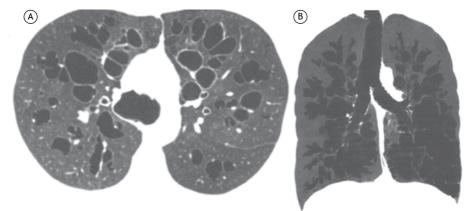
In A, chest CT during inspiration showing bilateral bronchiectasis, in addition to marked dilation of the main bronchi. In B, coronal reconstruction in minimal intensity projection showing, in addition to bronchiectasis, dilation of both the main bronchi and the trachea. These alterations characterized Mounier-Kuhn syndrome.
